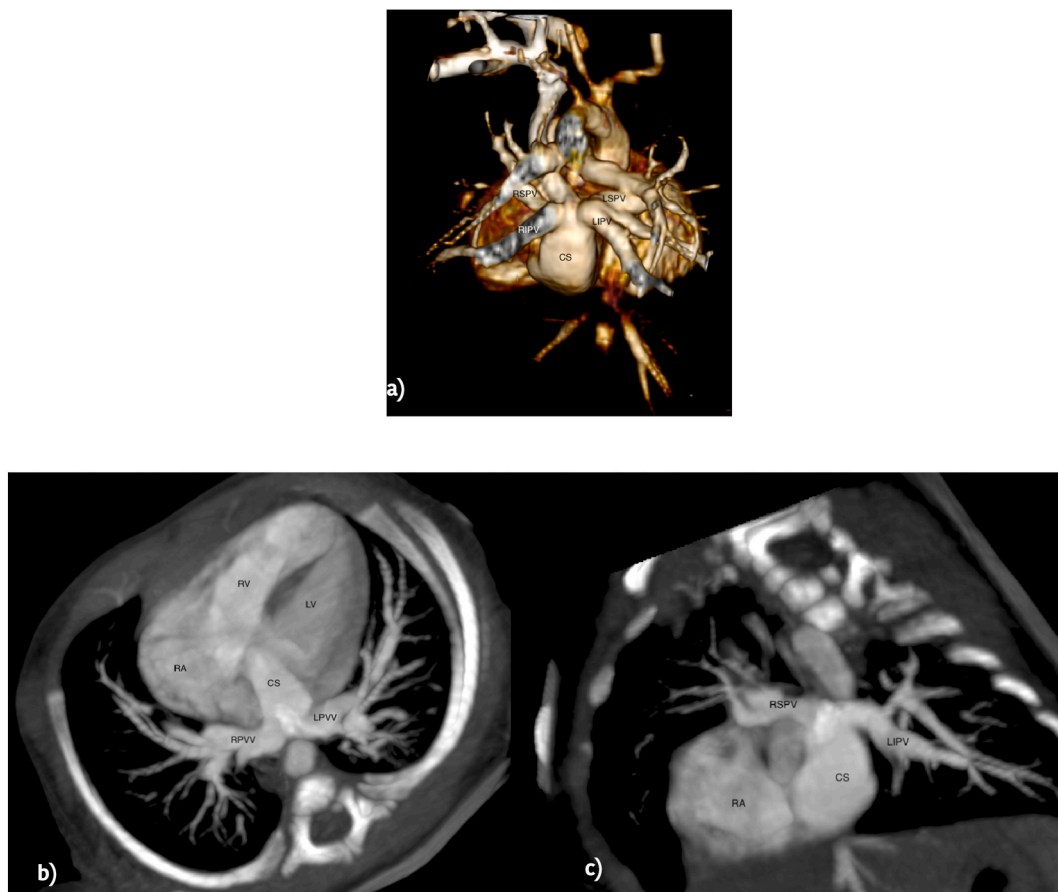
Contrast-enhanced computed tomography 3D VR (a), para-axial (b) and para-sagittal (c) MPR reconstruction of type II TAPVC draining in RA via an enlarged CS in a complex CHD. CS = Coronary sinus; LV = Left ventricle; RV = Right ventricle; RSPV = Right superior pulmonary vein; RIPV = Right inferior pulmonary vein; LSPV = Left superior pulmonary vein; LIPV = Left inferior pulmonary vein; RPVV = Right pulmonary veins; LPVV = Left pulmonary veins.
